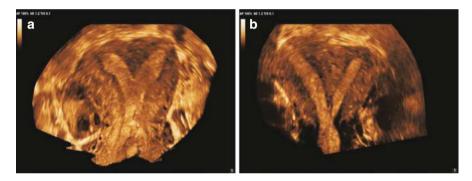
(a) Coronal view on 3D ultrasound showing a "Y-shaped" endometrium in an incomplete uterine septum. (b) Coronal view on 3D ultrasound showing a "V-shaped" endometrium in a complete uterine septum
